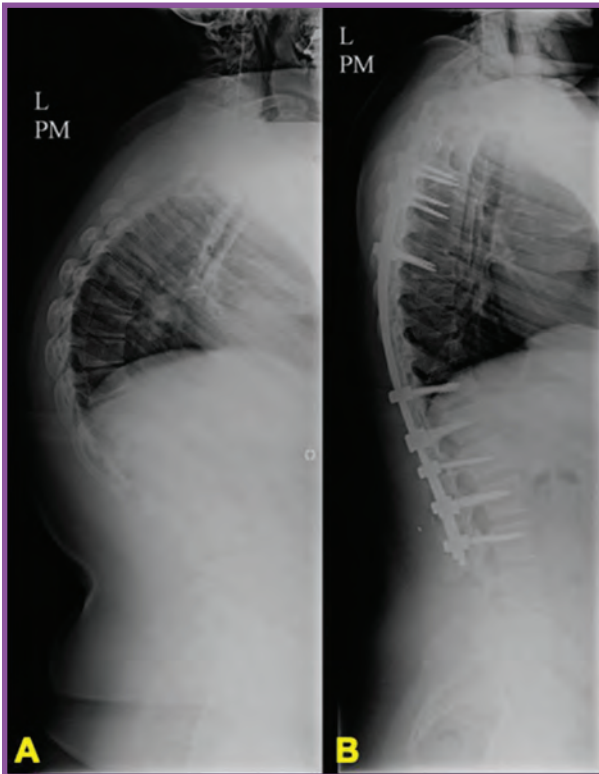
Radiographs from a 19-year-old with severe Scheuermann kyphosis of 95 degrees (A) who underwent posterior spinal fusion with instrumentation and experienced marked improvement in back pain (B).
